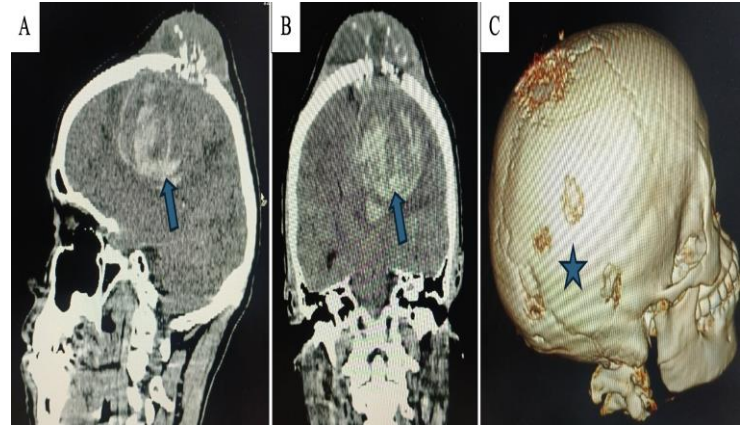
Non-contrast CT of the brain demonstrating a massive intratumoural haemorrhage. 3D reconstruction shows multiple skull lesions consistent with aggressive multifocal disease.
